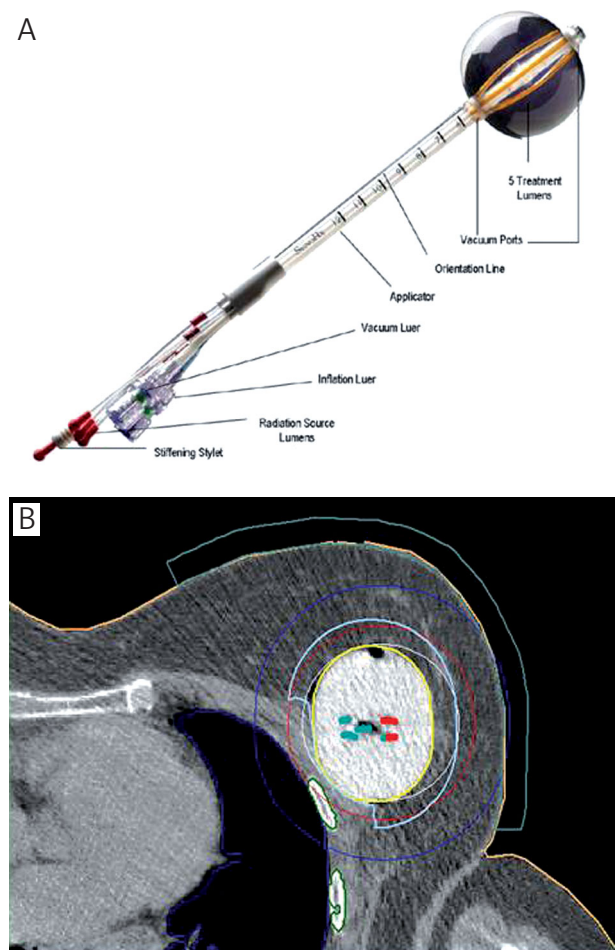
A) MammoSite device used in balloon brachytherapy (Hologic®, Marlborough). B) MammoSite balloon applicator in CT cross section with the indication of lung
